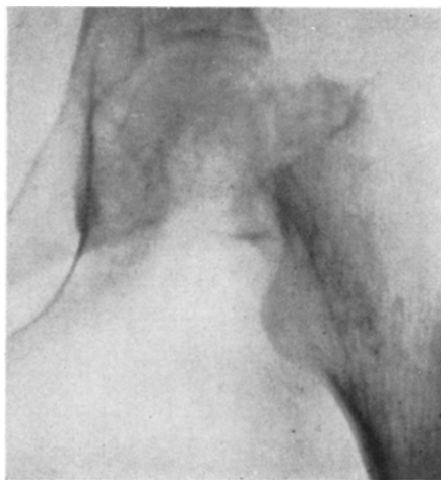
Case XIX. Roentgenogram after eleven weeks in traction, December 29, 1936; no trace of union, marked external rotation.
